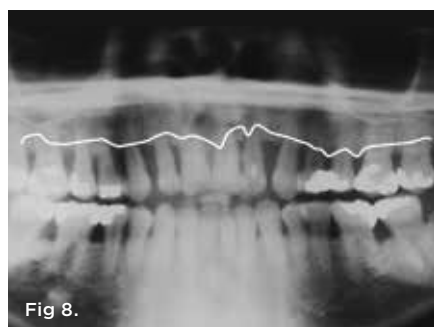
This 34-year-old woman presented with generalized aggressive periodontitis. She had experienced rapid attachment loss with up to 50% loss of alveolar bone as evidenced by this panoramic radiograph. Fig 9. The patient after customized oral hygiene instructions were given and SRP was performed. Note the quality of the soft tissue and minimal visible inflammation. However, 8 mm interproximal probing depths still remained on the day of surgery. Fig 10. Palatal flap was elevated using the papillary retention design. The buccal flap and papillae were not elevated. Fig 11. Use of individual interproximal vertical mattress sutures enabled a more tension-free closure, which minimized papillary recession. Fig 12. The knots of the sutures were placed palatally to avoid further cosmetic compromise during healing. Silk sutures were used in this case, but the authors recommend 5-0 or 6-0 ePTFE or polyglactin sutures for periodontal surgery to prevent bacterial wicking. Fig 13. Three years after surgery, pocket depths were 2 mm to 3 mm. Fig 14 and Fig 15. Palatal view at initial presentation (Fig 14) and 3 years post-surgery (Fig 15). At initial presentation, note heavy calculus, gingival inflammation, rolled gingival margin, and palatal gingival recession. At 3 years post-surgery, note the improved gingival health and maintenance of the interproximal papillae with apical positioning of the palatal tissues.
